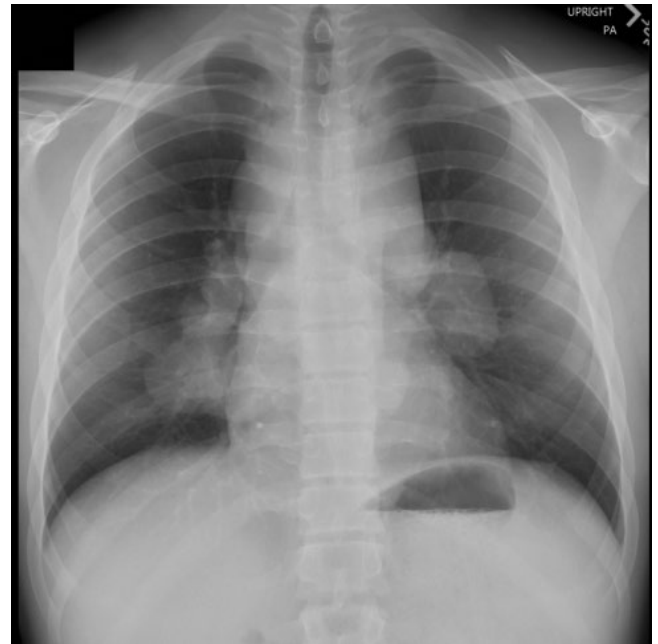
Chest radiograph of a 7-month-old patient with anterior mediastinal mass.
